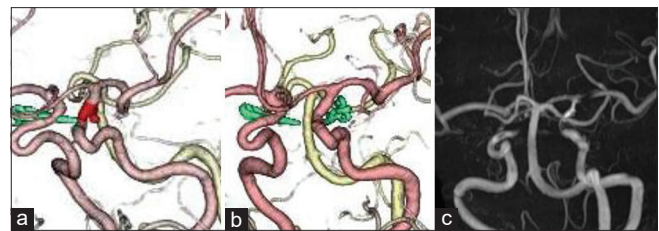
Computed tomography angiography showed a 5-mm unruptured aneurysm of the left internal carotid-anterior choroidal artery (a). During operation, fibrin glue-soaked oxidized cellulose was also used with polyurethane-coated surgical cotton patty to control the bleeding from a pinhole injury of the M1. One week after surgery, computed tomography angiography showed no configuration change of the left M1 (b). One year after surgery, magnetic resonance angiography confirmed no configuration change of the left M1 (c) resonance angiography confirmed no configuration change of the left M1
